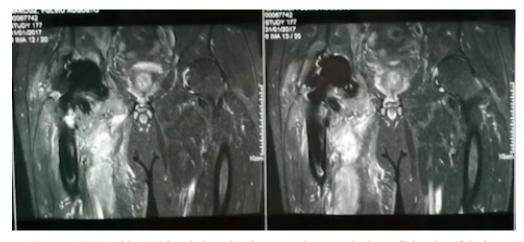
MRI with MARS technique showing a pseudotumour in the medial region of the leg.
